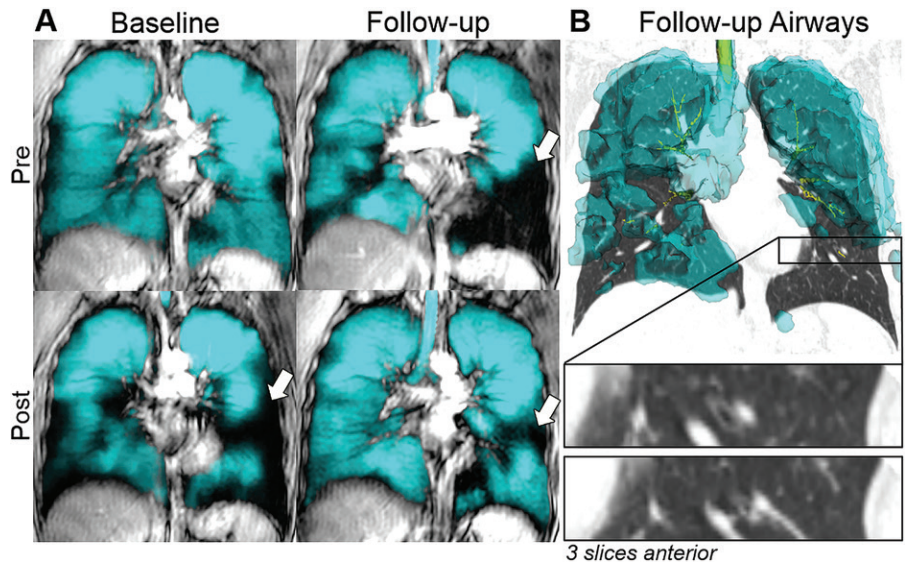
Images show helium 3 (³He) MRI ventilation in a 36-year-old woman (participant S01) with mild-to-moderate asthma and worse ventilation at 6-year follow-up. A, Center coronal section ³He ventilation MRI (cyan, administered as an inhaled contrast agent) coregistered anatomic hydrogen 1 MRI (gray scale) for baseline pre-methacholine challenge (pre) and after methacholine challenge (post), and follow-up before (pre) and after (post) bronchodilator. Worsened defects were shown between visits (arrows). B, Follow-up three-dimensional ³He MRI shows ventilation coregistered to CT with three-dimensional airway tree at oblique angle. Inset on top (coronal view) shows LB8 bronchus leading to worsened follow-up defect. Lumen appears clear and open but is abruptly truncated within three sections anteriorly (inset on bottom). Participant S01 was a woman with mild-to-moderate asthma (baseline and follow-up, respectively: age, 36 and 41 years; forced expiratory volume in 1 second, 2.28 L and 1.71 L; ventilation defect volume, 270 mL and 780 mL).
